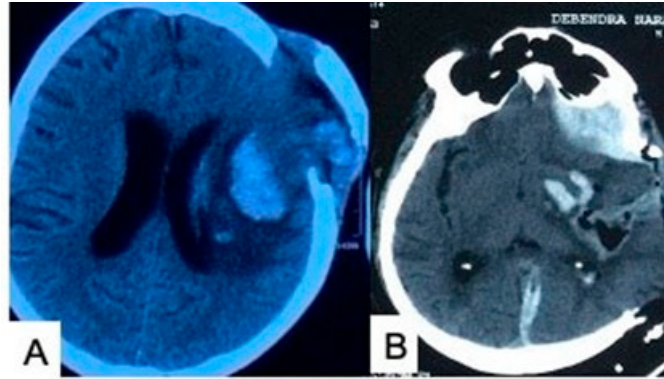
(A) CT scan showing brain swelling following surgery. (B) CT scan showing a residual hematoma with a perilesional edema, causing a raised ICP and extracalvarial herniation. Source: Figure by authors.
